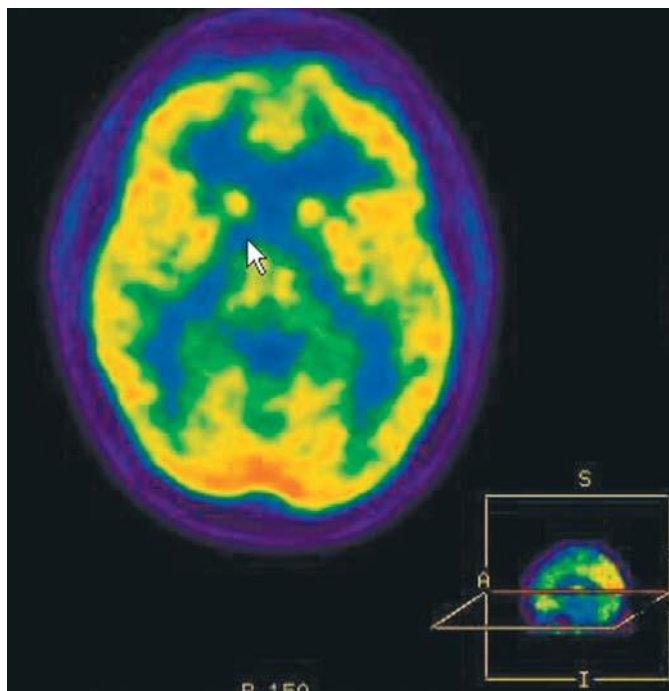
Axial brain PET-CT image. (Courtesy of Radiation Oncology Department, Lahey Clinic.)
